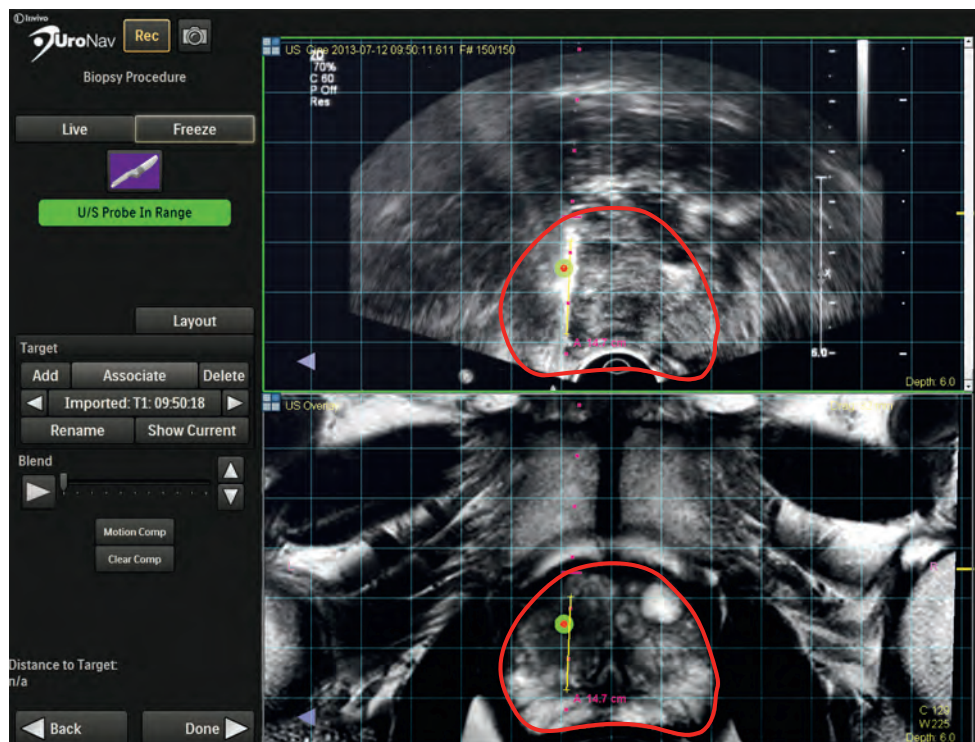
Example of a screen shot when performing transrectal ultrasonography (TRUS) using the UroNav (Invivo) TRUS–magnetic resonance imaging (MRI) fusion biopsy system. Upper panel is the real-time ultrasound; lower panel shows the MRI. The red line outlines the prostate and the green circle with the red dot represents the coregistered lesion of interest. The yellow line represents the needle tract. (Courtesy Dr. Peter Pinto, Urologic Oncology Branch, National Cancer Institute, Bethesda, MD.)
